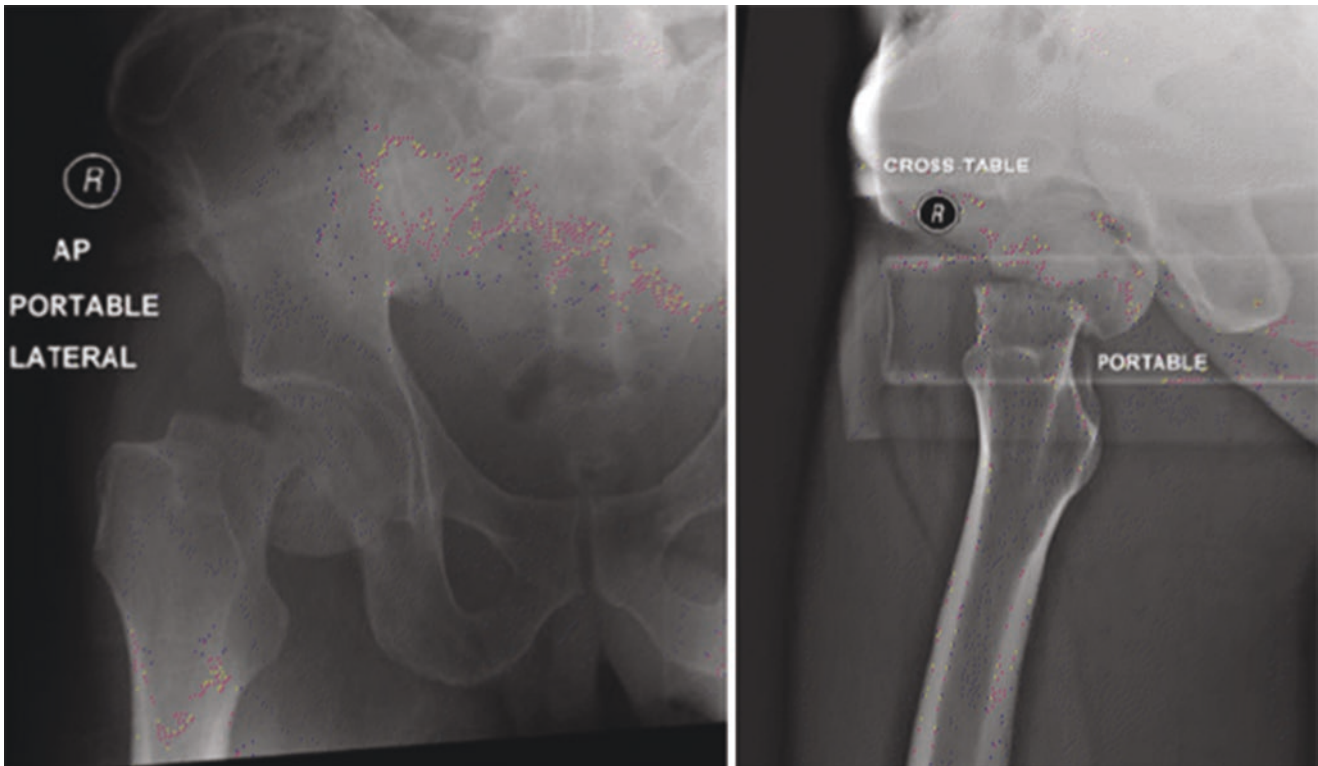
AP and cross-table lateral radiographs of a right hip showing a displaced femoral neck fracture [143] (Fig. 1 In Makhni, M. 2017. “Femoral Neck Fractures.” In *Orthopedic Emergencies*, edited by Eric Swart and Charles Day, 285. Springer)
